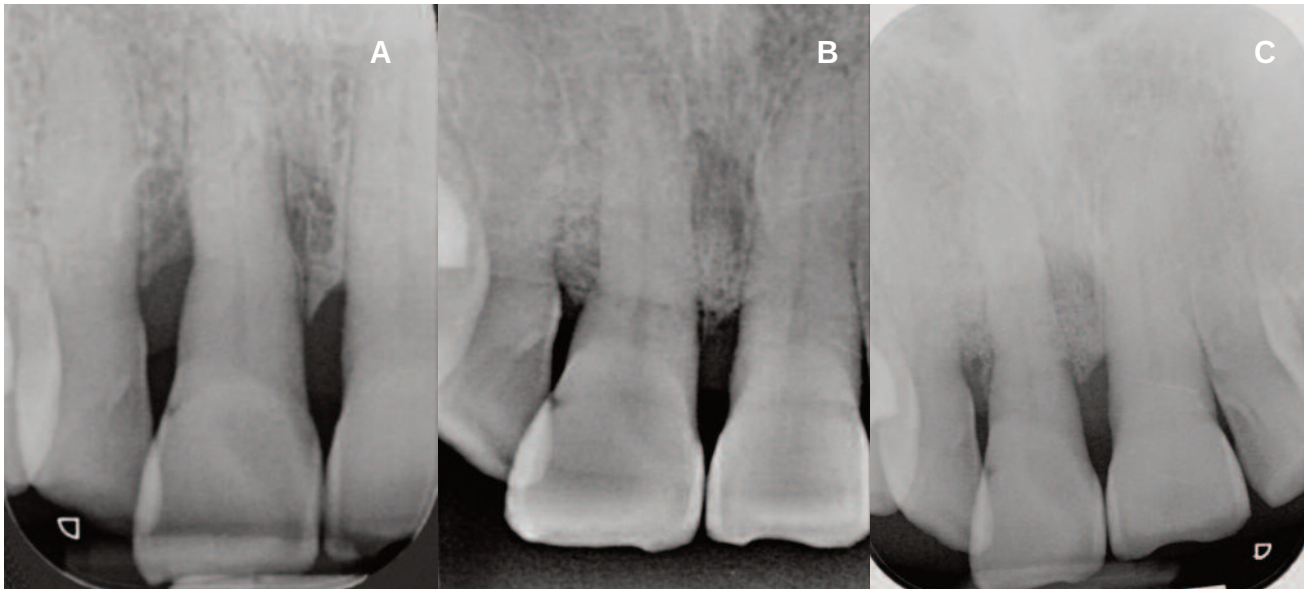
Radiographic progression of the case up to 9 months after surgery: a. Initial radiograph; b. Radiograph at 2 months; c. Radiograph at 9 months.
